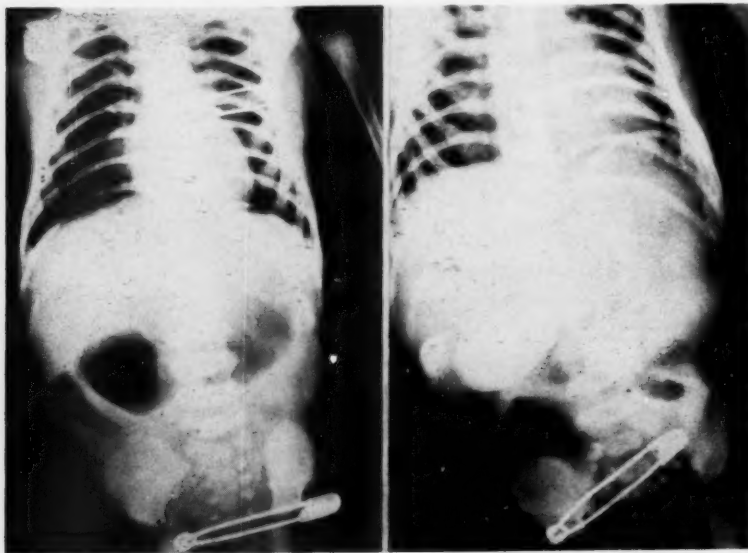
Roentgenogram showing the distended, gas-filled stomach and duodenum.
